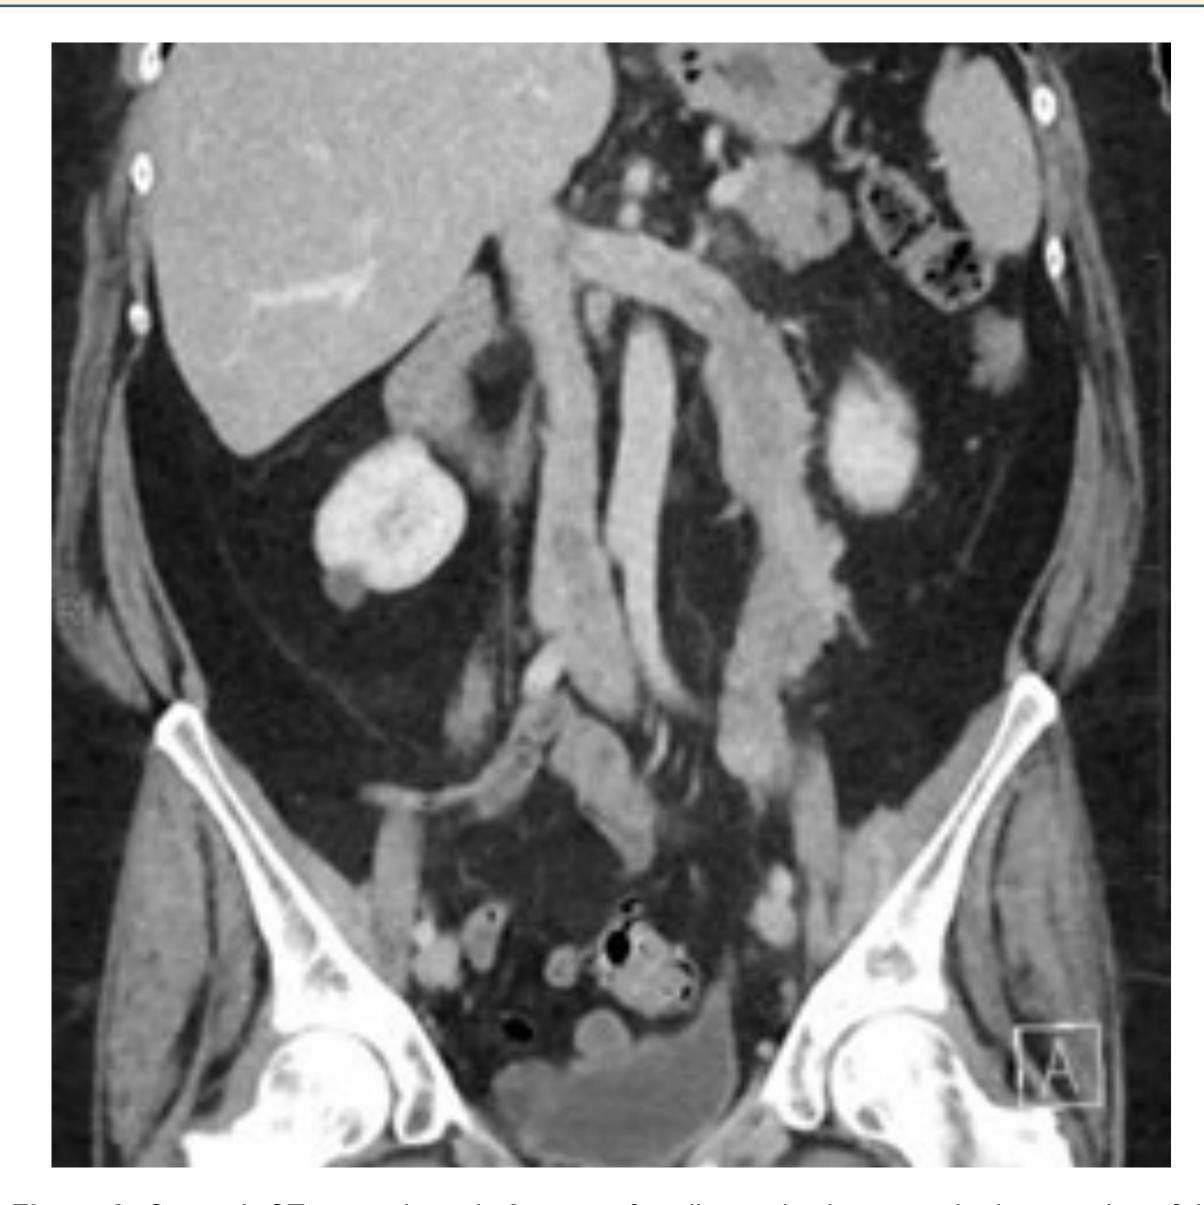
Coronal CT approximately 2 years after diagnosis shows marked expansion of the left gonadal vein with relatively hypodense intravascular tumor, and additional intravascular tumor involving the left common iliac vein at the confluence with the inferior vena cava.
